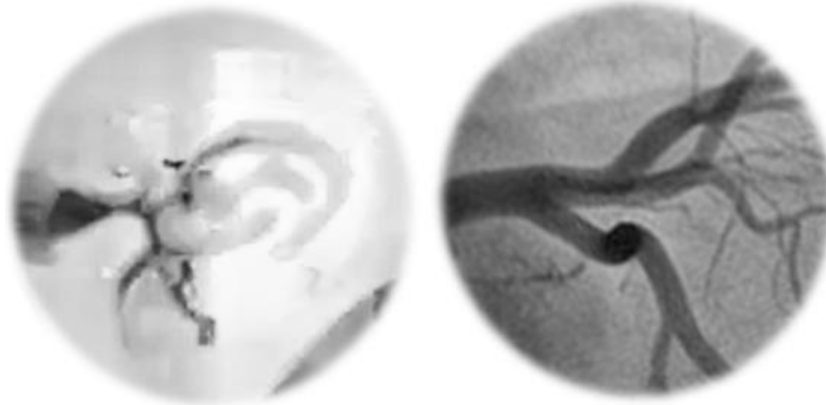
Validation of the scanned image between *CardioVASS* device (left) and phase-contrast MRI (right)
